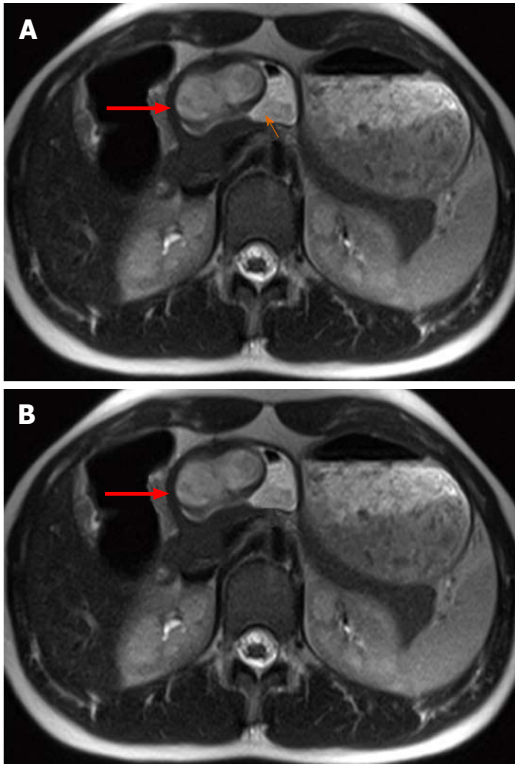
Magnetic resonance imaging findings for case 1, using transverse T2- and T1-weighted magnetic resonance imaging. A: Transverse T2-weighted magnetic resonance imaging (MRI) showing well circumscribed, endophytic mass (thick red arrow) of the gastric antrum which is partially filled with fluid (thin orange arrow); B: T1-weighted MRI after contrast media application showing homogeneous wall enhancement of the well circumscribed mass (thick red arrow).
